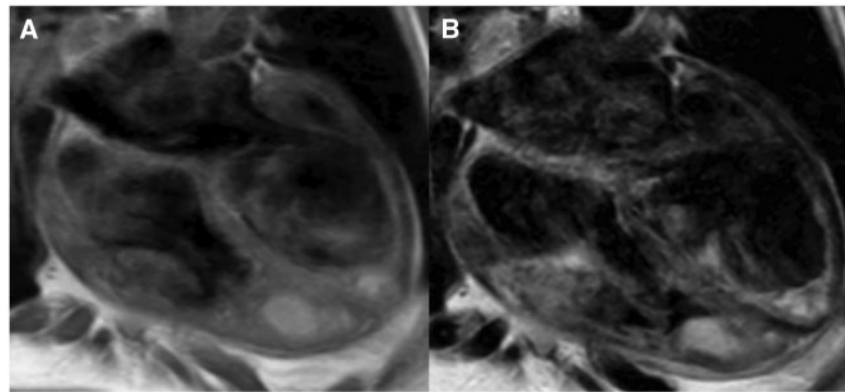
Cardiac magnetic resonance imaging in four chamber views showing high intensity signal for the intracardiac masses on T1 (A) and T2-weighted (B) black blood sequences, suggestive of acute thrombi.
